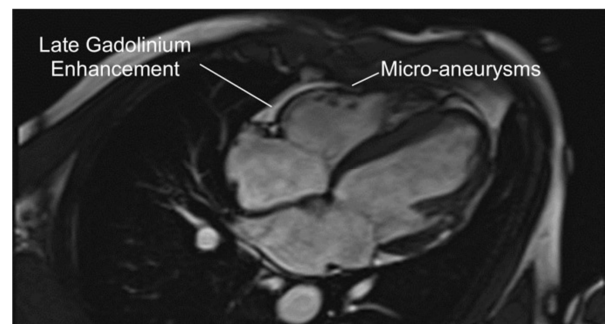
Four-chamber view of cardiac magnetic resonance imaging revealing evidence of right ventricular enhancement following gadolinium study.
